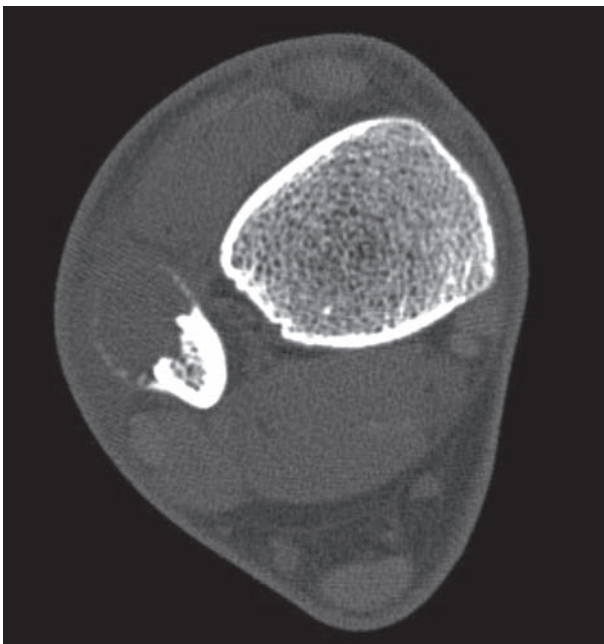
Non-contrast computed tomography showing an osteolytic lesion with thinning and infiltration of the cortex
